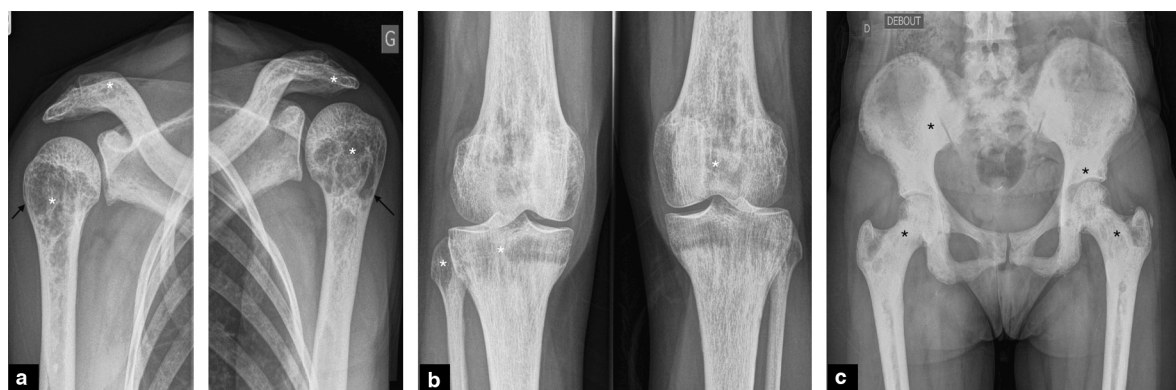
a: radiographs showing multilocular lytic lesions of the left and right humerus, b: radiographs showing multilocular lytic lesions of the knees; c: radiographs showing sclerosis of the pelvic bone. The white asterisks show the location of the multilocular lytic lesions. The black asterisks indicate the sclerosis of the bone. The arrows show the endosteal lysis.
